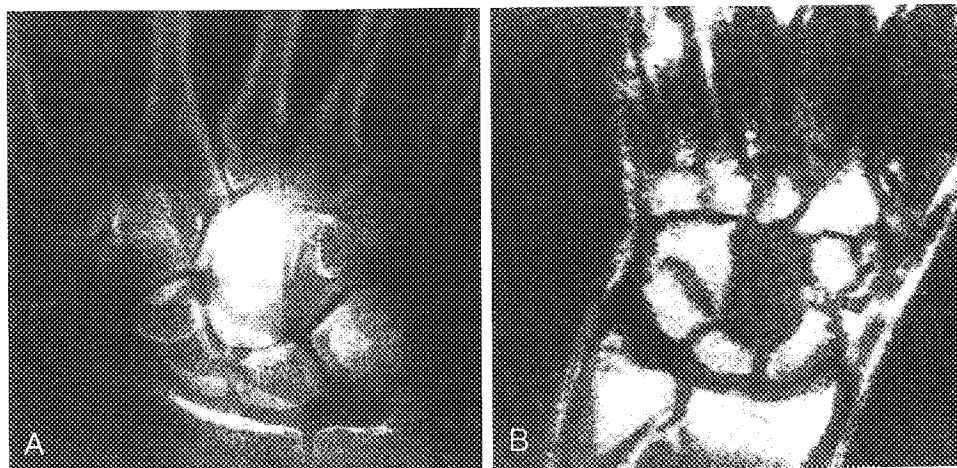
A, Anteroposterior radiograph of the wrist demonstrating radiodensity of the capitate. B, Coronal MR image of wrist showing corresponding area of signal void. (From Trumble *et al.* [17]; with permission.)
